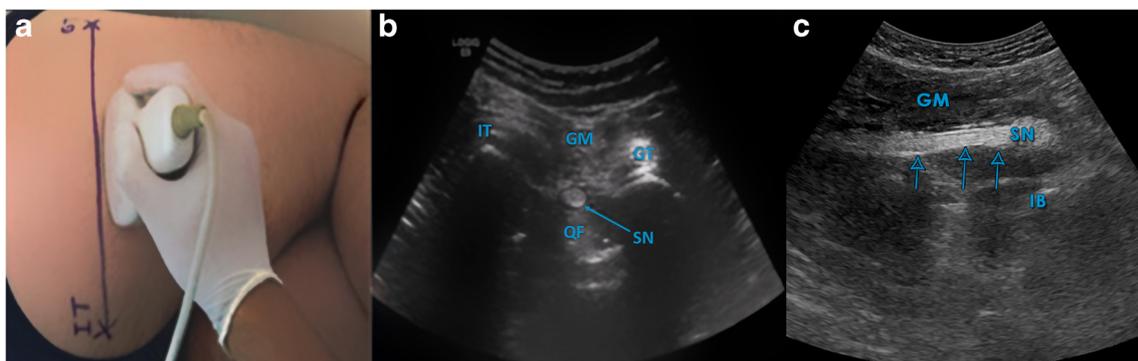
a Image showing the probe position and anatomic orientation. B-Mode ultrasound image shows the sciatic nerve. b Gluteal approach sonographic appearance in axial plane. c Gluteal approach sonographic
